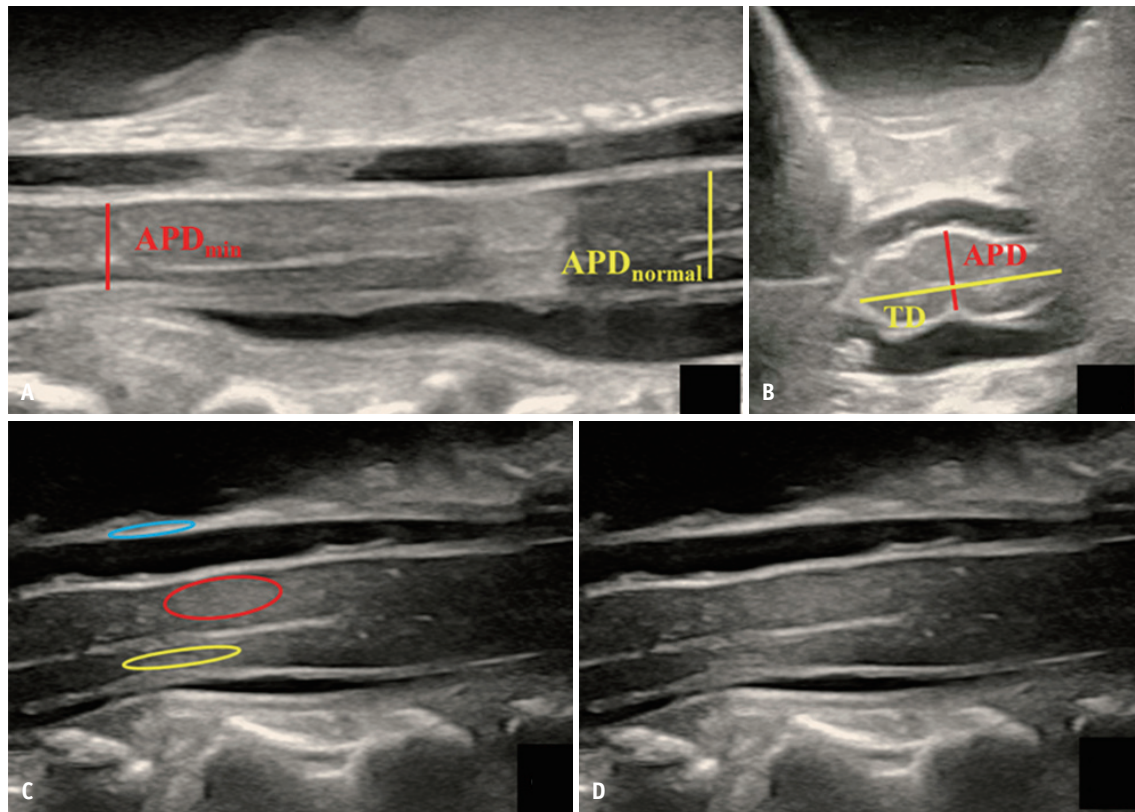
Intraoperative ultrasound image measurements.
